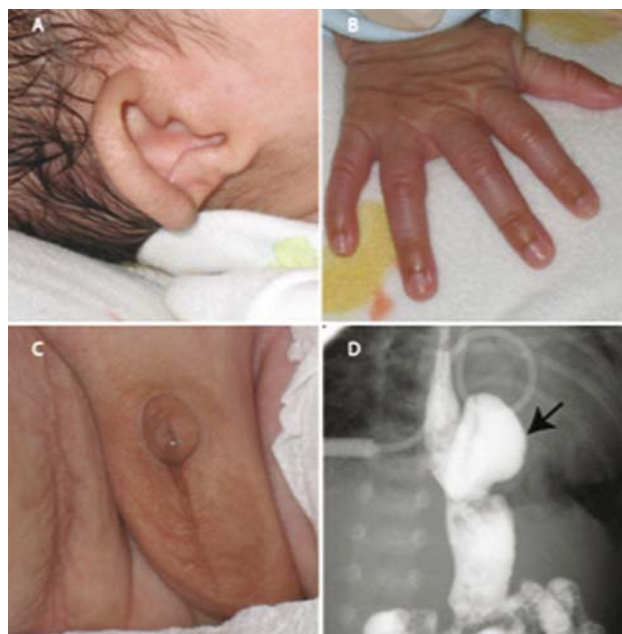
Phenotypic features and upper gastrointestinal (UGI) radiographic study of the patient. His facial features included crumpled ears (Panel A). He had long, slender fingers (Panel B). Genital hypoplasia was also present (Panel C) with stretched penile length of 2 cm. Panel D demonstrates intrathoracic stomach (arrow) on UGI study.
